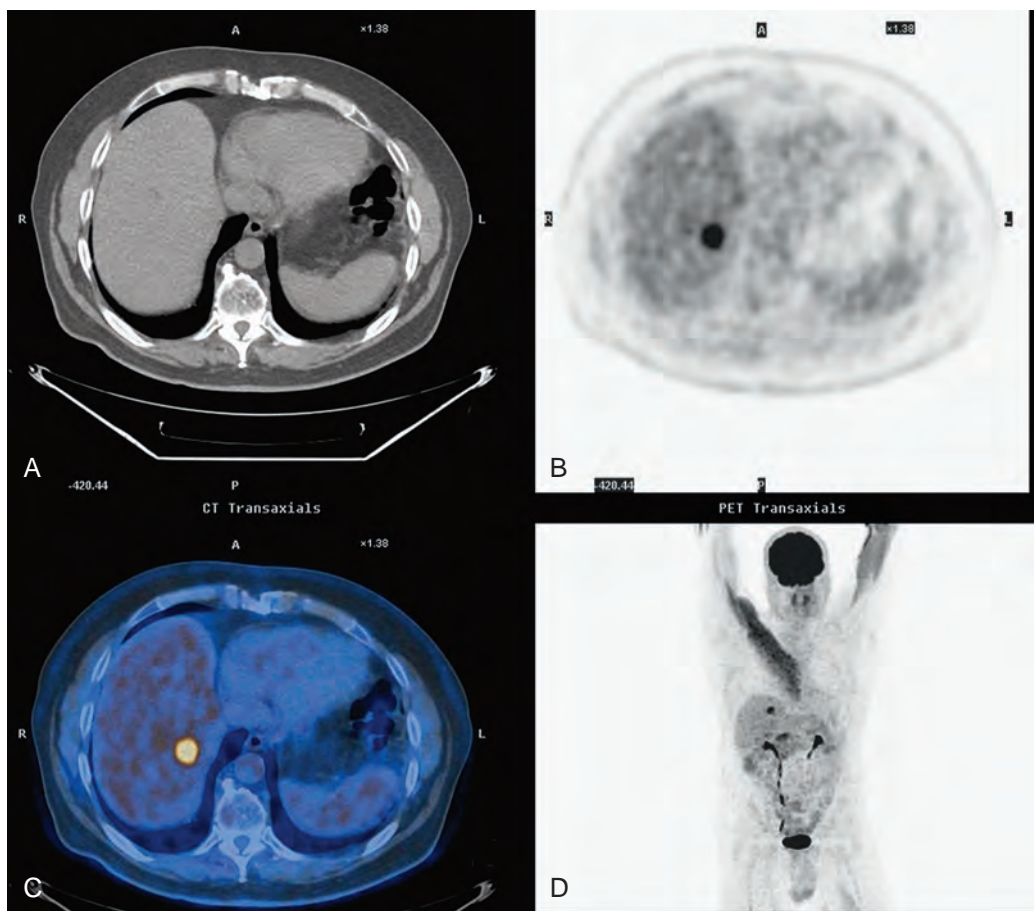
Hepatic metastases: PET/CT. A. Axial, unenhanced CT shows no mass. B. PET image at the same level shows uptake of ^{18}F -FDG in the right lobe. C. Fused image provides precise localization of the colon cancer metastasis. D. Whole body PET image shows the solitary hepatic metastasis.
